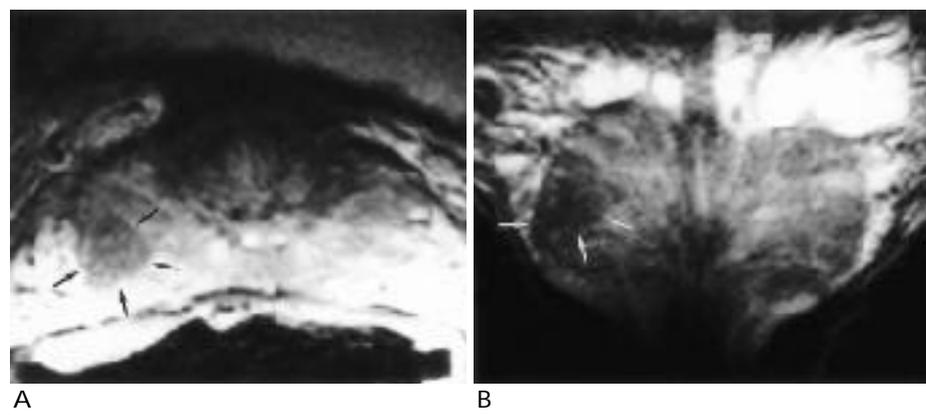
A pathologically proven stage T2a prostate carcinoma. A. Axial FSE T2-weighted MR image shows a focal round hypointense lesion in the right peripheral zone of the prostate (arrows). Due to the preservation of the capsule, the lesion was presumed to be confined within the gland. B. Coronal FSE T2-weighted MR image shows a focal hypointense lesion in the right peripheral zone of prostate (arrows).
